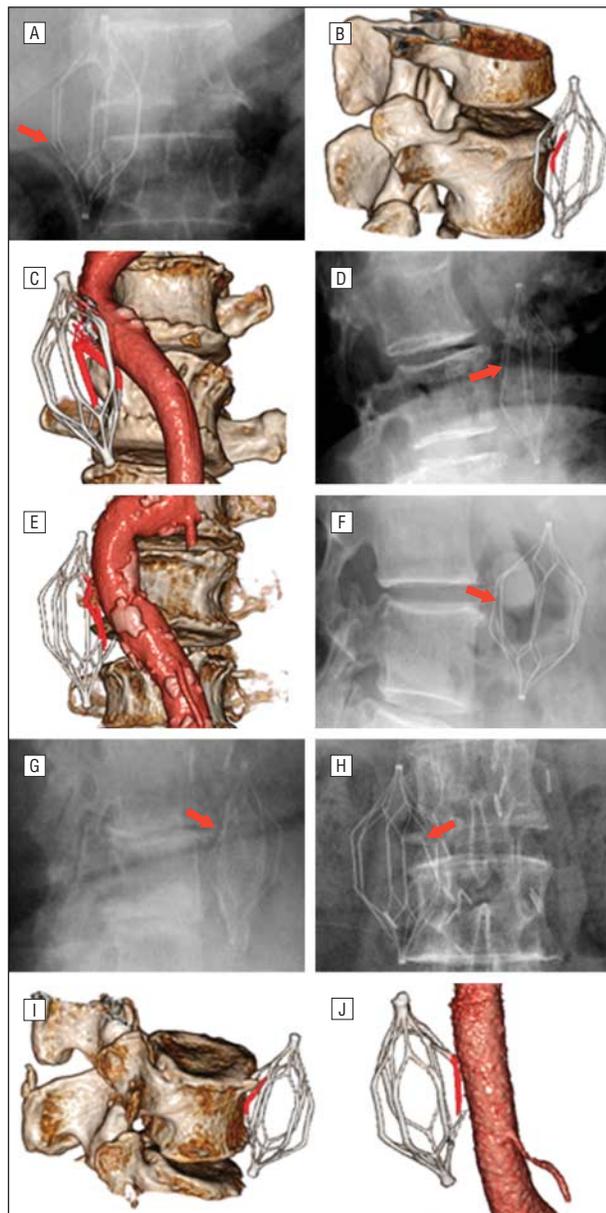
Radiographic examinations and 3-dimensional images of filter fracture cases. A, Case 6; B, case 7; C, case 8; D, case 9; E, case 10; F, case 15; G, case 16; H, case 18; I, case 19; and J, case 20 (eTable; <http://www.archinternmed.com>). Arrows show the fractured struts. In cases A, B, D, F, G, H, and I, a single strut was fractured because of the compression of the vertebral body. In case J, a single strut was fractured because of the compression of the tortuous aorta. In cases C and E, 2 struts were fractured because of the compression of the body and tortuous aorta.
